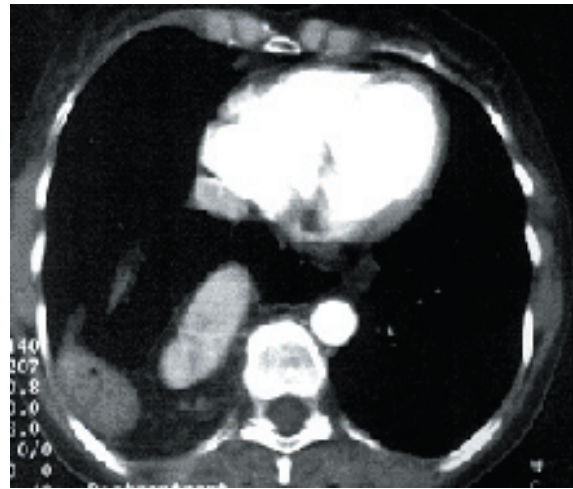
An axial CT image shows the spleen in the right side of the chest and a large diaphragmatic defect at the midline.
